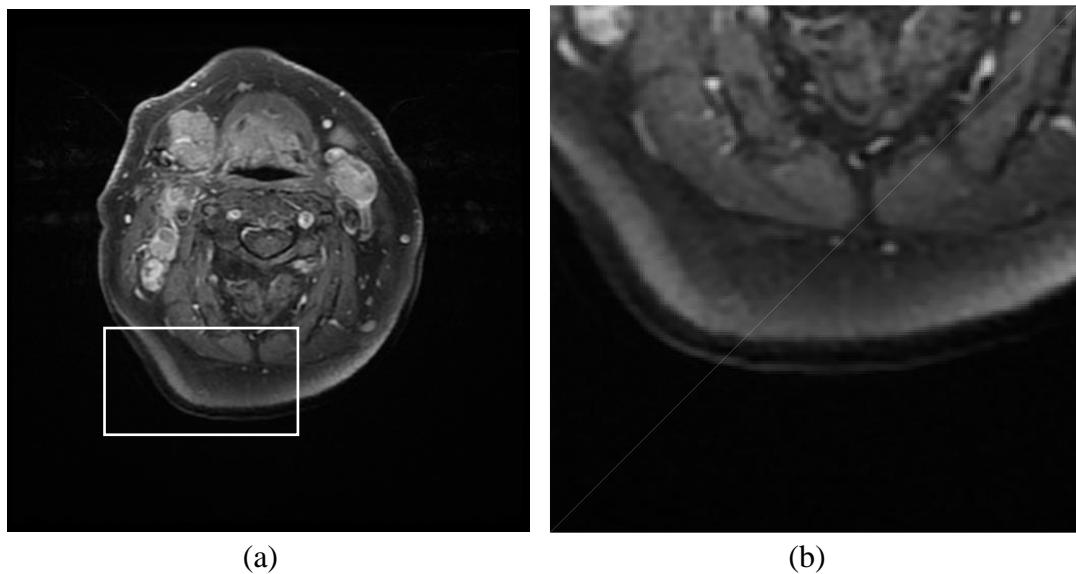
The Gibb's ring effect. (a) an MRI slice. (b) zoomed region of left slice (a) (marked with box in left image).
